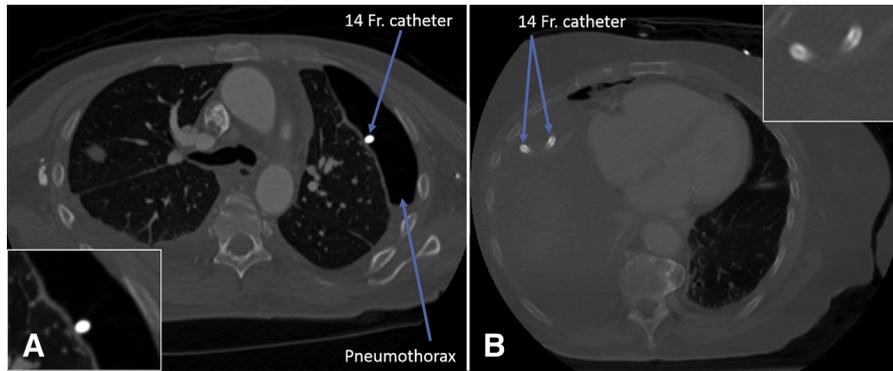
Computed tomography appearance. (A) At left, patient with retained catheter obturator. The 14.0-Fr catheter is visible in cross section, within the pleural space. A pneumothorax is visible. Of note, the catheter appears solid (inset, lower left), not hollow, even on window settings that typically highlight air—another indication that the obturator remains in place. (B) A different patient, with the same catheter type inserted, without the obturator. The catheter tip is curled as expected and also appears hollow (see inset, enlarged, upper right). Both images are depicted with bone windows (C570/W3077).
